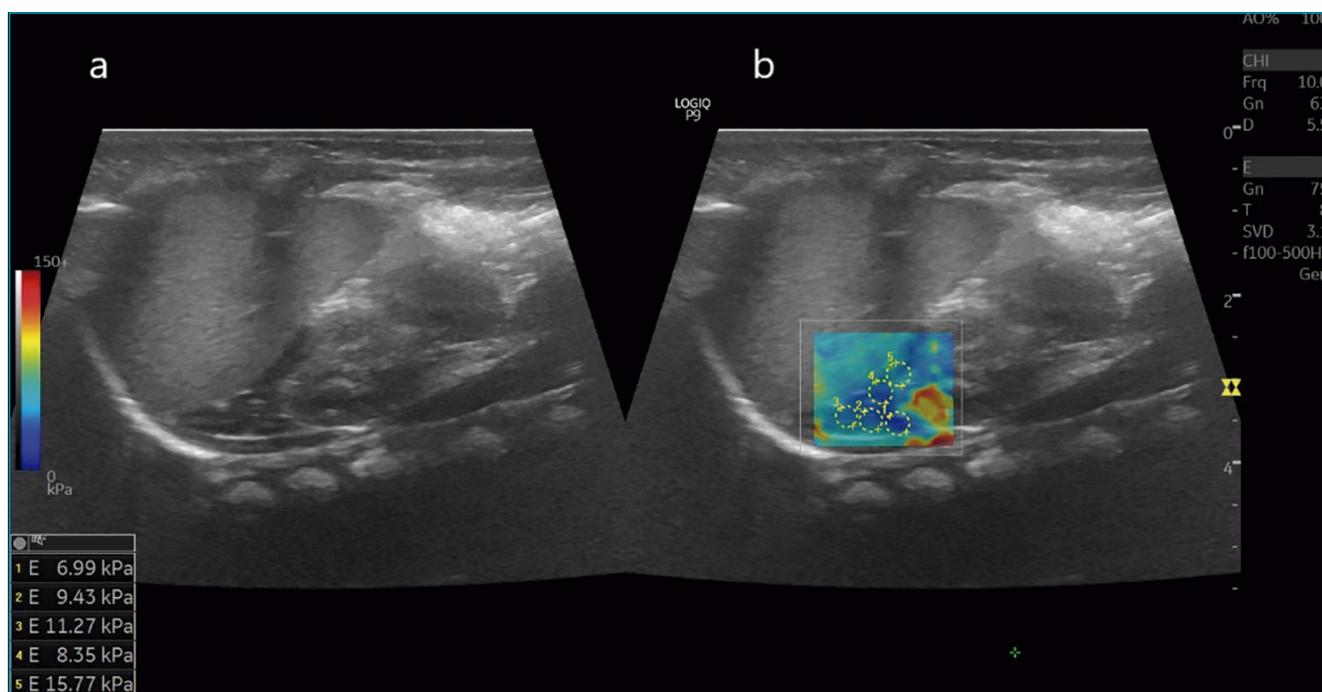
A 14-day-old male healthy newborn. Normal right adrenal gland was shown in B-mode ultrasound (a) and standard shear-wave elastography (b) imaging, superomedial to the kidney and inferior to the liver. (a) B-mode ultrasound: triangular shape right adrenal gland is depicted, and (b) standard shear-wave elastography imaging: a square region of interest with a color elastogram map is depicted along with the smaller circular region of interest with elastogram measurements.
